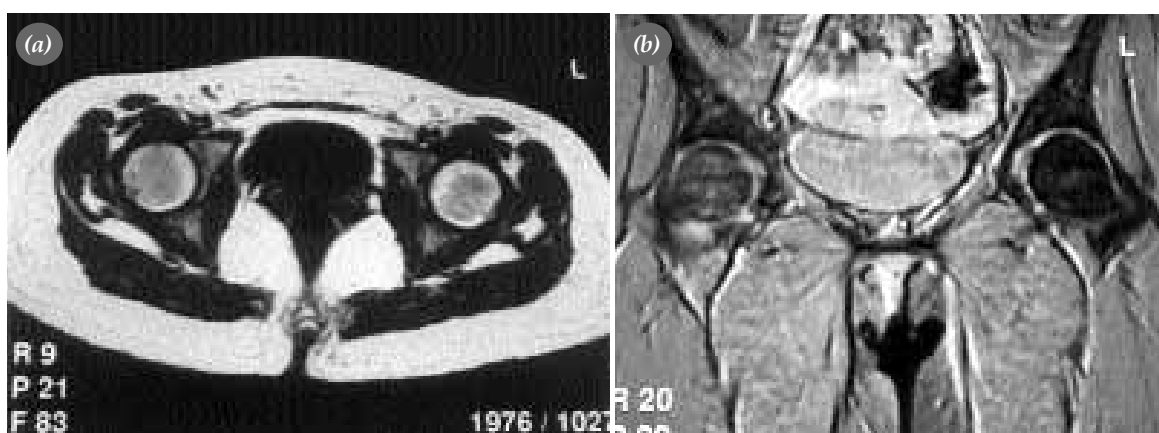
In case number 2, MRI showed no effusion in the proximal femur, but signal density (a) decreased in T₁-weighed sequences, and (b) increased in T₂-weighed sequences.
